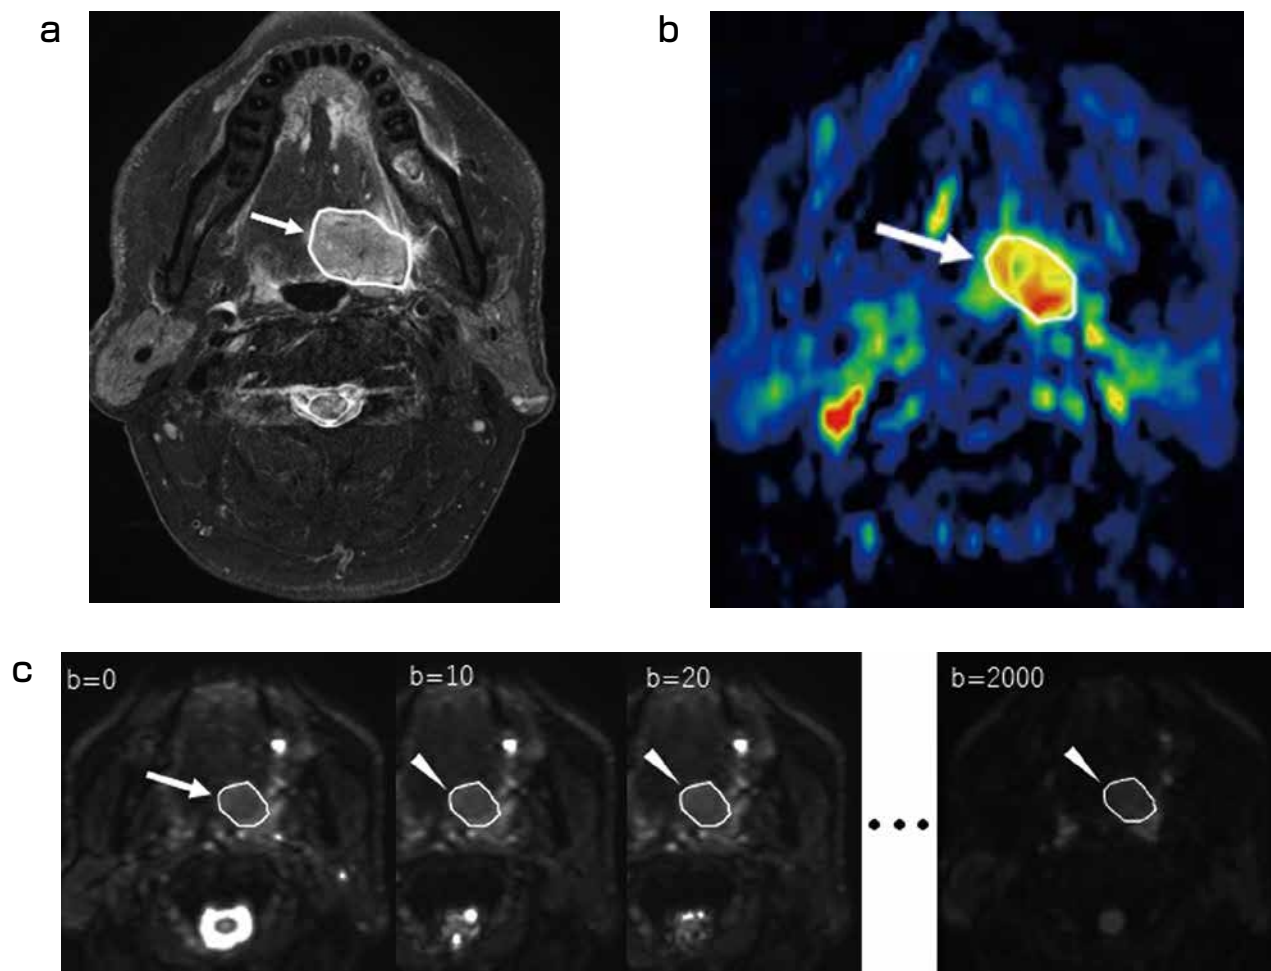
Tumor ROI delineation. Each primary tumor was firstly outlined by a polygonal ROI on Fs-T2WI (a ; arrow). Subsequently, primary tumor on ASL perfusion images (b ; arrow) and b_0 images of DWI (c ; arrow) were delineated with reference to the Fs-T2WI ROI so that the same region was outlined among Fs-T2WI, ASL and DWI. For the DWI analysis, the tumor ROI on the b_0 image was then copied on the EPI of the respective b -values (c ; arrowheads).
